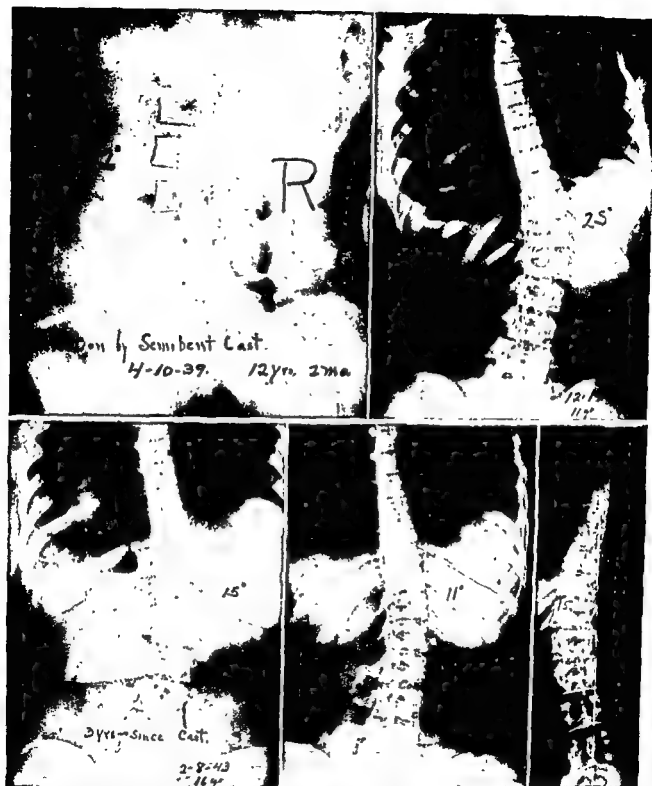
(Top, left) An 11-year-old girl with 25° dorsolumbar curve. No iliac apophysis showing. She was corrected with a semibent antigavity cast, giving 12° of over-correction. (Top, right) Shows the girl in a semibent jacket with the curve bent against itself. The curve has been reduced from 25° to 12° to the opposite side. The iliac apophysis is well capped (Bottom, left) Three years after cast. (Bottom, center) Six years after cast (Bottom, right) Roentgenogram taken 18 years later shows that the patient is maintaining her correction at 15°, making a total of 10° maintenance of correction during the past 20 years. The lesson to be gained is that the iliac apophysis completion was a guide as to when the cast should be removed in those cases in which correction was maintained only by the cast and not by fusion. (Risser, J. C.: Am. Acad. Orthop. Surgeons Instructional Course Lectures 14:91, Ann Arbor, Edwards)
